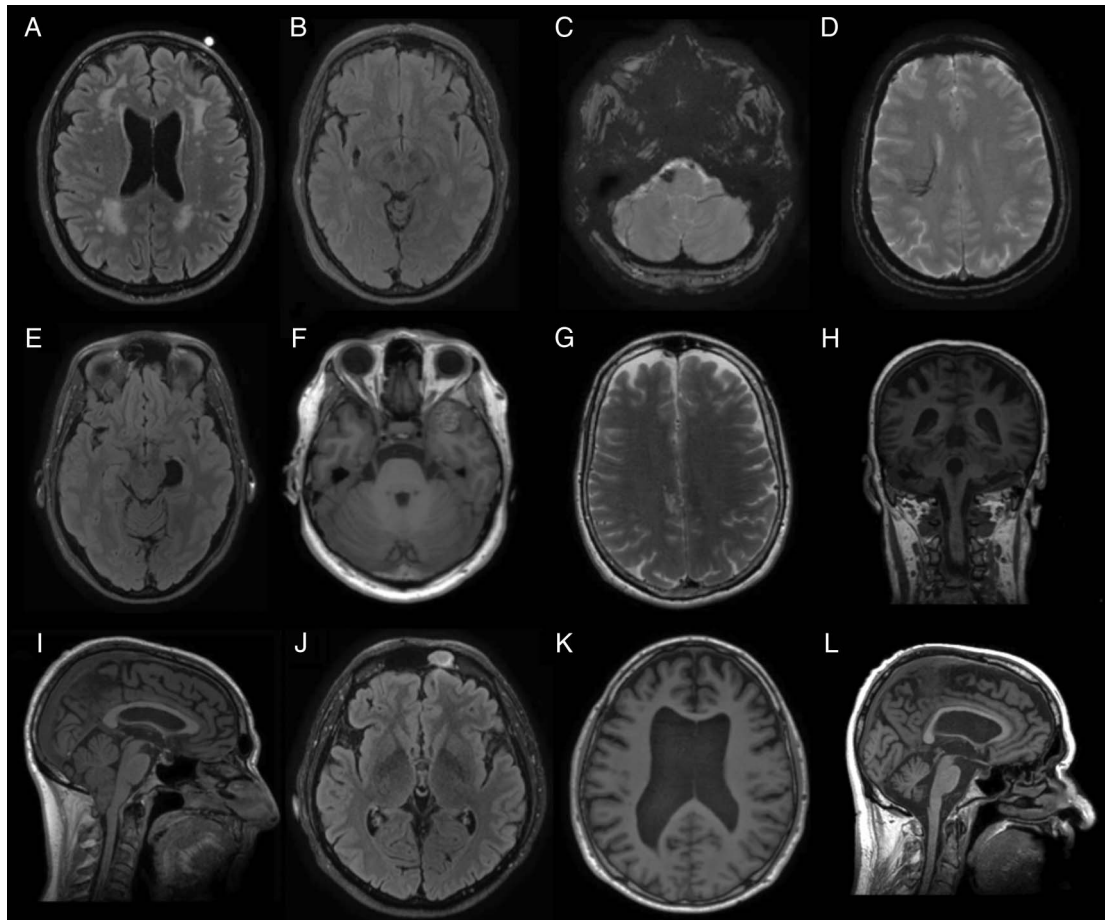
Incidental findings on brain MRI. (A) White matter hyperintensities. (B) Lacunar infarct. (C) Cavernous malformation. (D) Malformation of venous development. (E) Arachnoid cyst. (F) Meningioma. (G) Non-specific focus of altered signal. (H) Brain volume loss. (I) Chiari malformation type I. (J) Otorhinolaryngology process. (K) Ventriculomegaly suspicious of NPH. (L) Brain stem atrophy.
